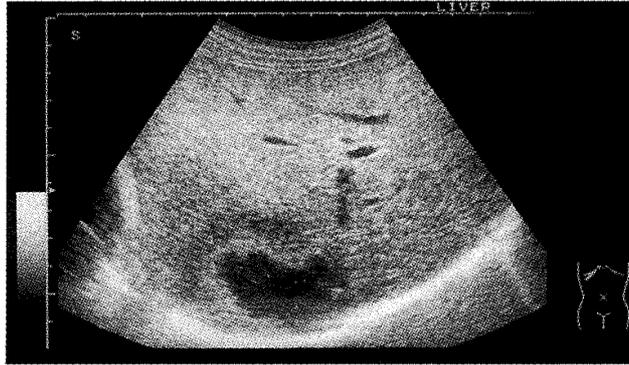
Abdominal ultrasonography: Abdominal ultrasonography was carried out one month later and showed a tumor measuring  $6.1 \times 4.6$  cm in the posterior superior sub-segment of the right lobe.
